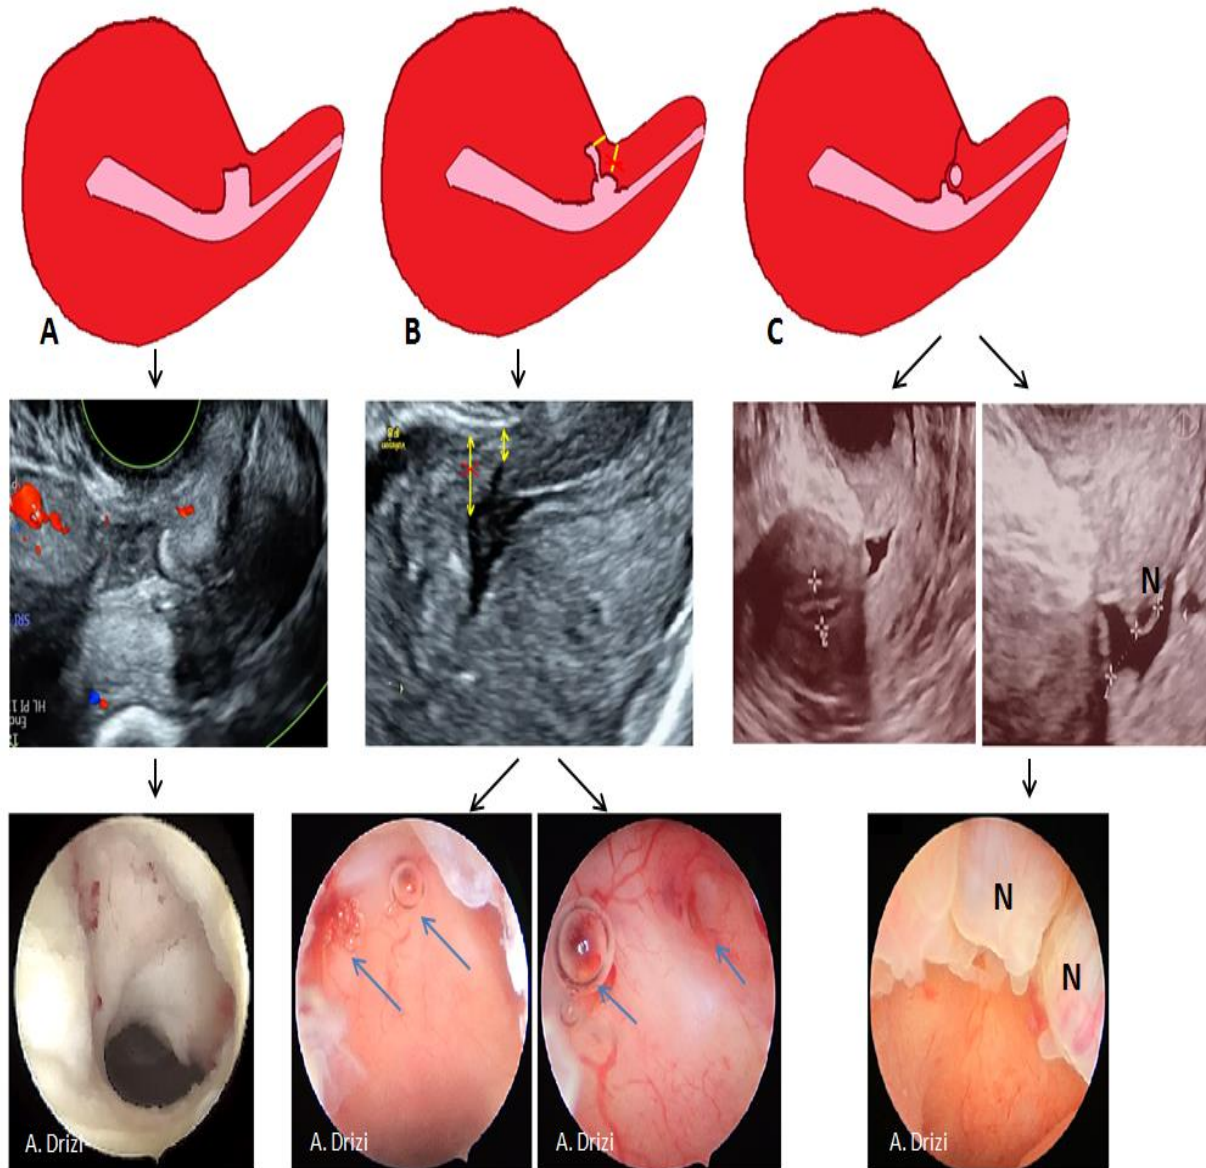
Complex anatomy of isthmocele with sonographic and hysteroscopic correlations. A: square-shaped niche; B: branch on the top of the niche with air bubbles passage at hysteroscopy through the orifices; C: Nabothian cyst near isthmocele. Yellow arrow: residual myometrium; Blue arrow: the orifice on the top of the niche leading to the branch with air bubbles passage (complex isthmocele). N: Nabothian cyst. Images by A. Drizi.
